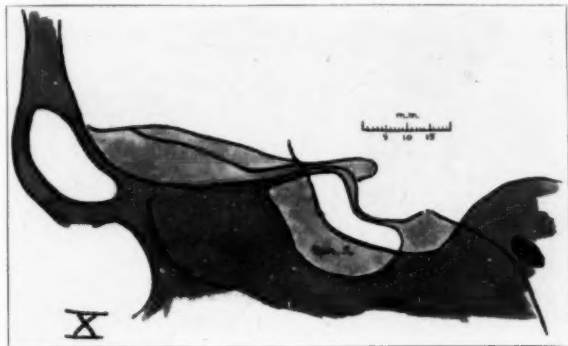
(case 10).—A sketch of the roentgenogram (fig. 31), drawn to scale.
